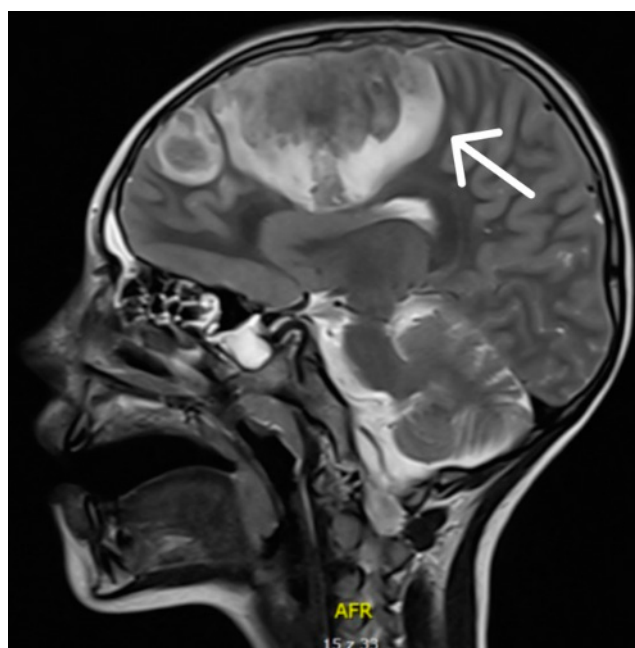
Head MRI with contrast from the second day of hospitalization, sagittal view
